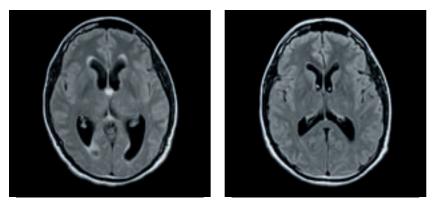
Axial FLAIR sequences are shown that indicate the total endoscopic removal of a colloid cyst. Comparison of the pre-operative(left) and postoperative (right) images demonstrates complete tumor removal, partial reduction of ventriculomegaly, and resolution of transpendymal fluid resorption.
